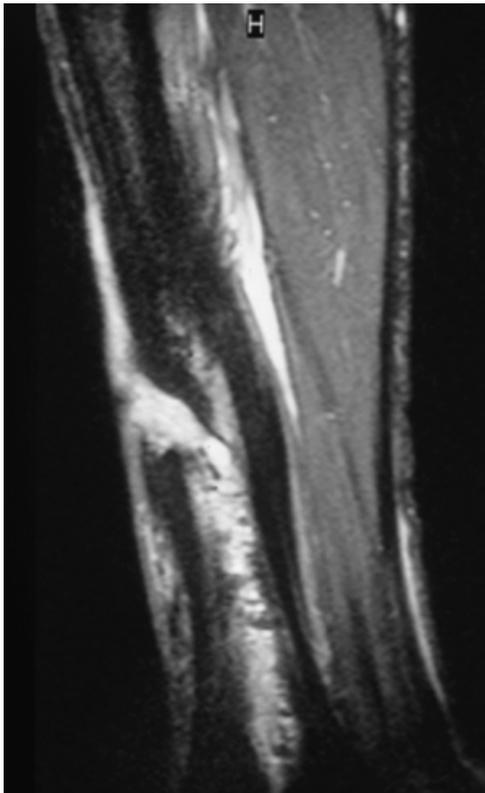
Magnetic resonance imaging of the left tibia showing fistulating osteomyelitis of the medullary canal.
